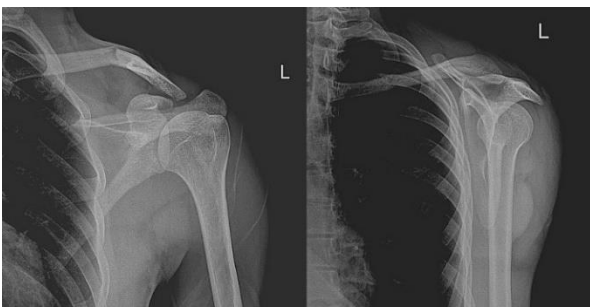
Preoperative shoulder anteroposterior and lateral radiographic images.
